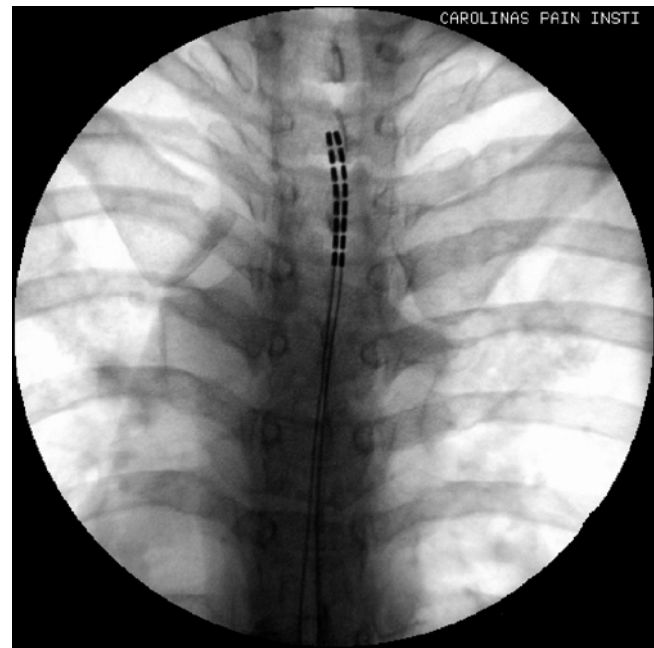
Fluoroscopic anterior-posterior (AP) radiograph of thoracic spine with appropriately positioned two octrode leads midline and with the tips positioned at T5. This is the most frequent lead positioning when used for the SCS in painful gastrointestinal disorders
